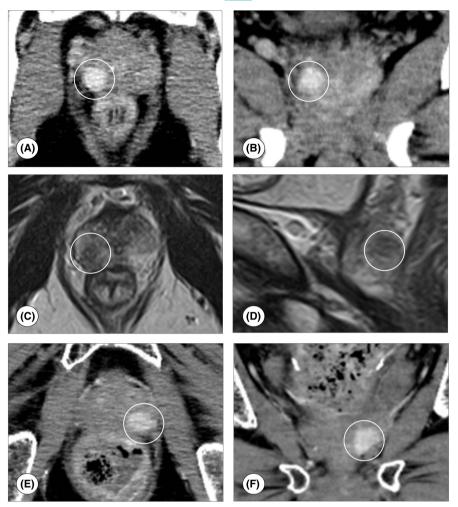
Computed tomography scans and magnetic resonance images. In case 1, computed tomography revealed a contrast-enhanced nodule in the right lobe of the prostate (axial [A] and coronal [B] view). The nodule was hypointense on T2-weighted magnetic resonance images (axial [C] and sagittal [D] view). In case 2, computed tomography revealed a contrast-enhanced nodule in the left lobe of the prostate (axial [E] and coronal [F] view)
